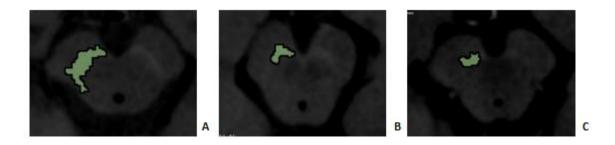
Neuromelanin (NM) are selection on NM sensitive magnetic resonance images of the SN of a healthy control (a), a de novo PD patient (b) and a LSPD patient;
